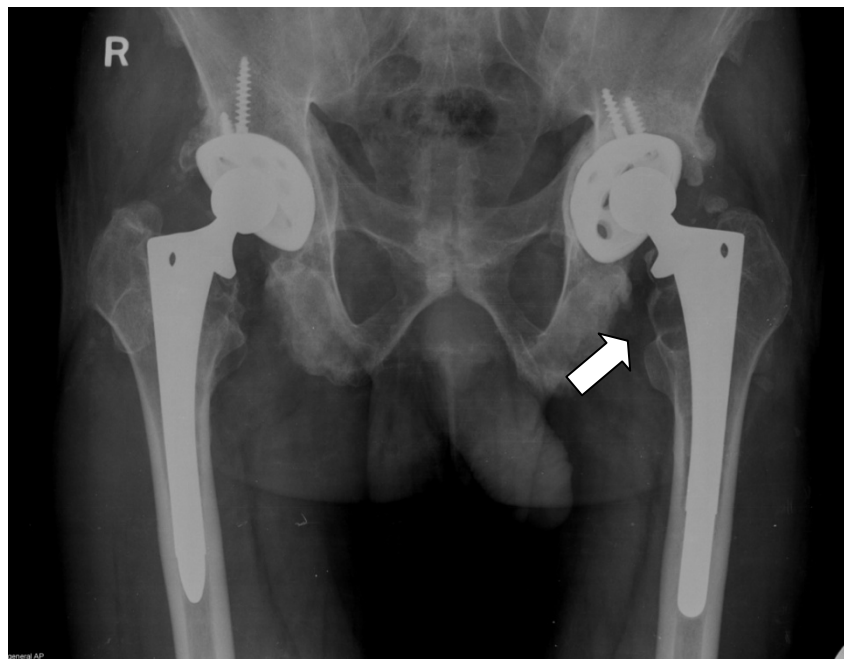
Immediate post operative and follow up radiograph. The lower radiograph shows proximal femur stress shielding and cortical hypertrophy at the tip of the stem.
